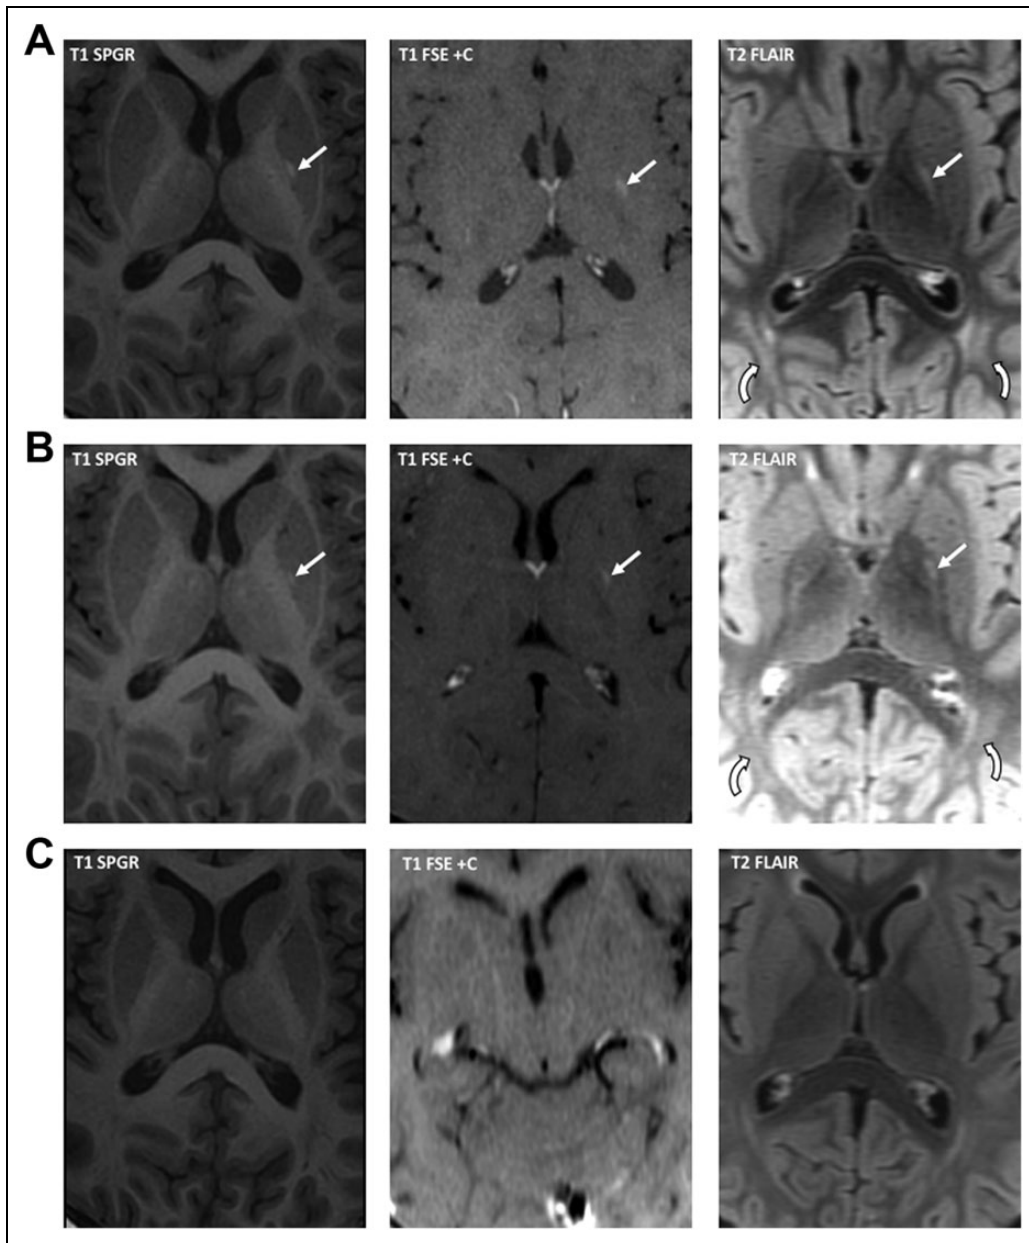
Successive axial images reconstructed through the level of the deep basal nuclei and ventricles, with different weightings: T1 Spoiled Gradient Recovery Echo (T1 SPGR), Postcontrast T1 Fast Spin Echo (T1 FSE +C), and T2 Fluid Attenuated Inversion Recover (T2 FLAIR). At the time of the initial magnetic resonance examination (A), there is a subtle focus of signal abnormality within the left lentiform nucleus, at the interface of the putamen and globus pallidus externa (straight arrow); this lesion is intrinsically T1 hyperintense and T2 FLAIR hyperintense, with suggested enhancement. This lesion is seen in addition to other patchy, nonenhancing T2 FLAIR hyperintense signal changes located symmetrically within the deep biparietal periaxial white matter (curved arrows); the parietal white matter signal abnormalities were initially interpreted as methotrexate-induced leukoencephalopathy. Over the course of the patient's treatment, these signal abnormalities within the left basal ganglia and biparietal white matter were gradually reduced (B), and eventually resolved (C).
